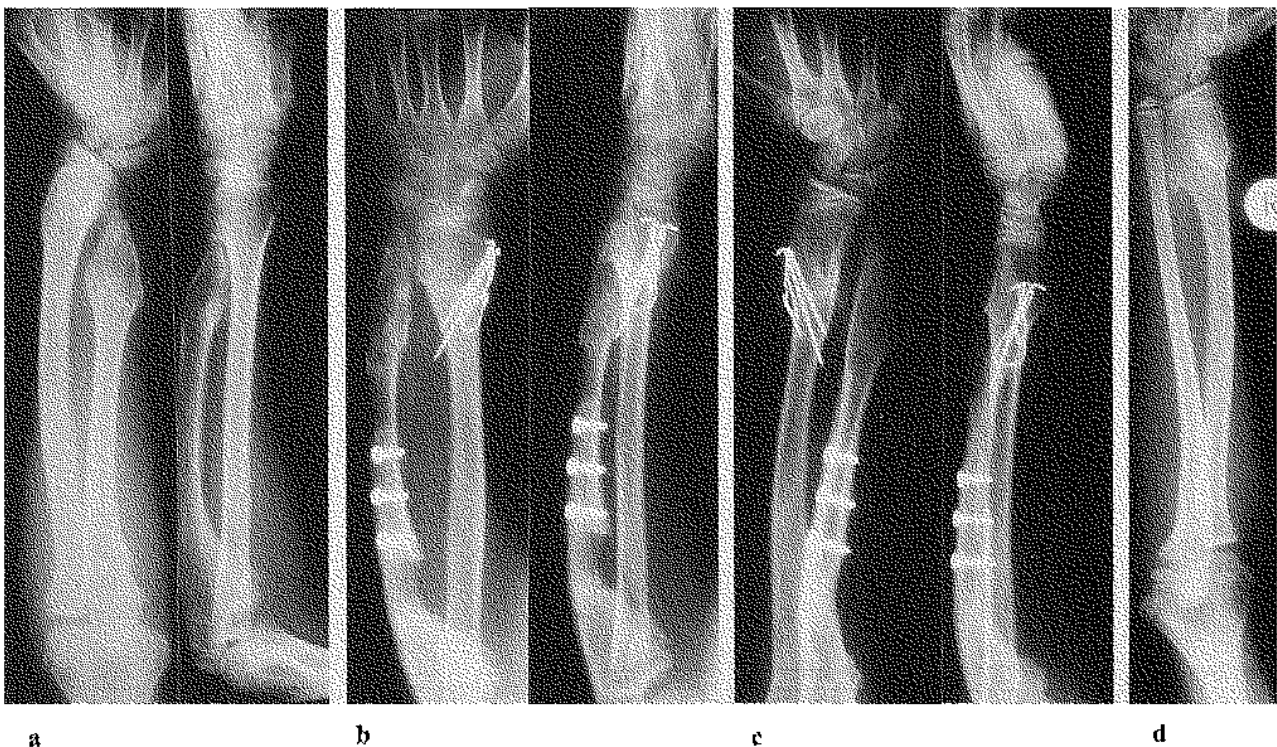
Radiographs of case 3 (the right side showing type I deformity and the left side showing type III deformity);
